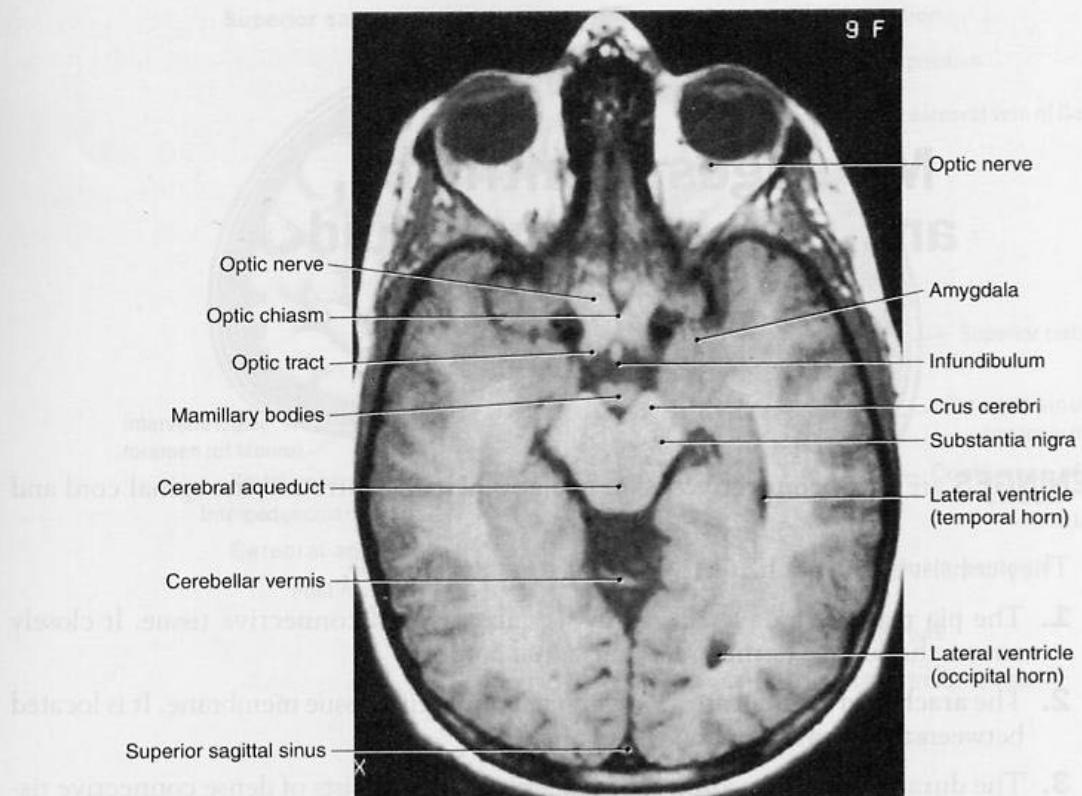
Axial magnetic resonance imaging section at the level of the optic chiasm, mamillary bodies, and midbrain. This patient has neurofibromatosis type 1 and an optic nerve glioma. Note the size of the right optic nerve. The infundibulum is postfixed. This is a T1-weighted image.
